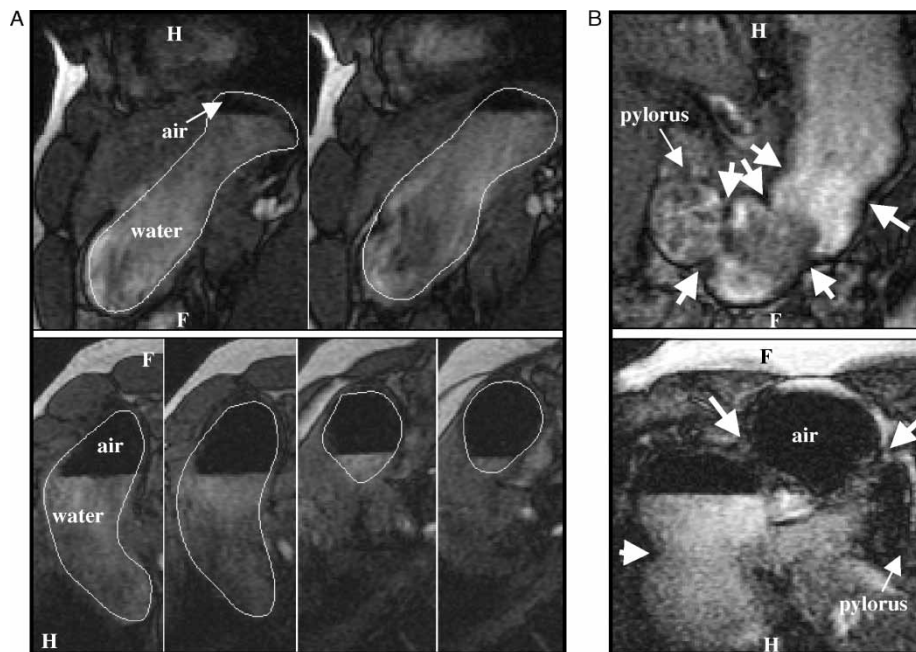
a. Consecutive sagittal images of MRI volume scans from a volunteer in seated position (SP) (*upper panel*) and upside-down position (UDP) (*lower panel*), respectively. Stomach contours are outlined in each image. The images demonstrate the prominent difference in intragastric meal (water) and air distribution (F: feet direction, H: head direction). b. Oblique coronal images of motility scan from the same volunteer in SP (*upper panel*) and UDP (*lower panel*). Peristaltic contraction waves (*white arrows*) and the position of the pylorus are indicated in the images. The UDP motility image nicely depicts that gastric air was confined to the distal stomach in this position (F: feet direction, H: head direction).
